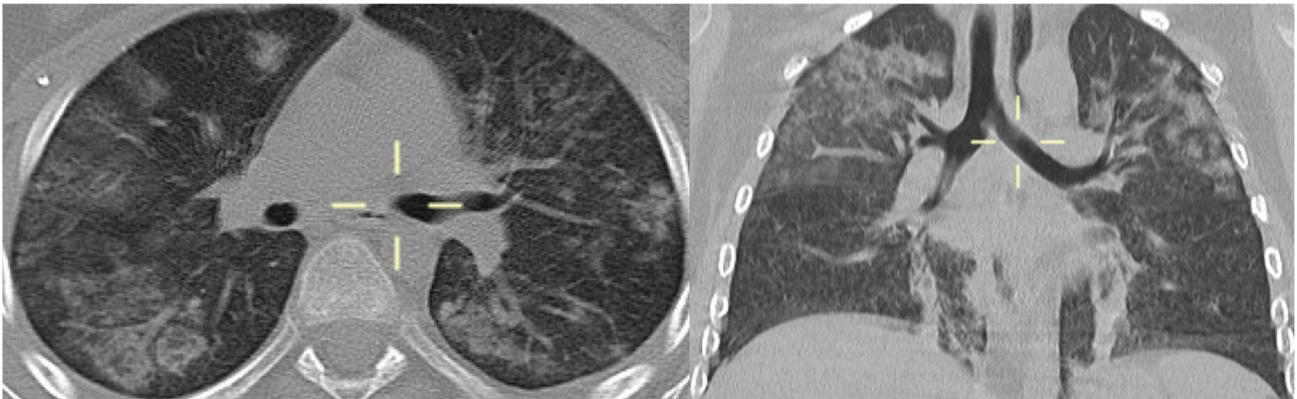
Axial and coronal CT reconstitution (patient 8)—diffuse bilateral alveolar consolidation partly confluent with typical perihilar distribution in the upper lobes.
